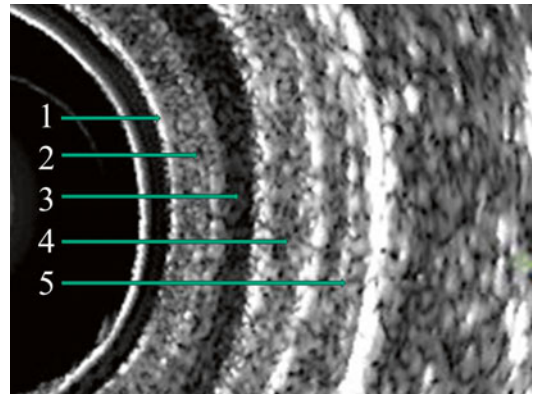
The ultrasonographic five layers of the normal anal canal: (1) the first hyperechoic layer corresponds to the interface of the transducer with the anal mucosal surface; (2) the second layer represents the subepithelial tissues and appears moderately reflective; (3) the third hypoechoic layer corresponds to the internal anal sphincter; (4) the fourth hyperechoic layer represents the longitudinal muscle; and (5) the fifth mixed echogenicity layer corresponds to the external anal sphincter
